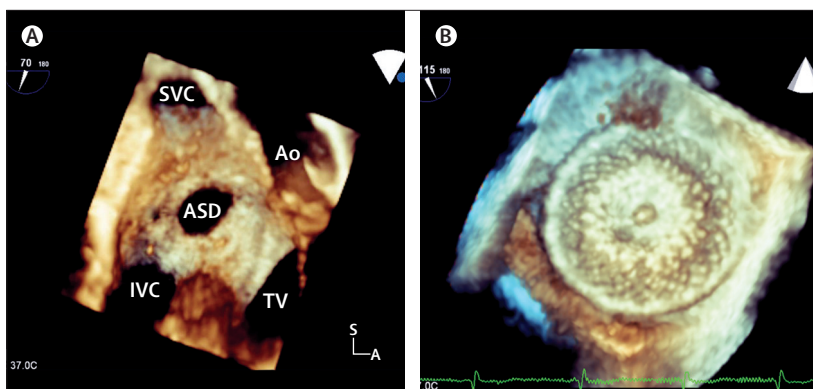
Three-dimensional imaging of a secundum atrial septal defect imaged by a transoesophageal echocardiogram before (A) and after (B) device closure (A) En-face view of the defect as seen from the right atrium. (B) En-face view of the occluding device as seen from the left atrium. Images are from different patients. Ao=ascending aorta. ASD=atrial septal defect. IVC=inferior vena cava. SVC=superior vena cava. TV=tricuspid valve.
